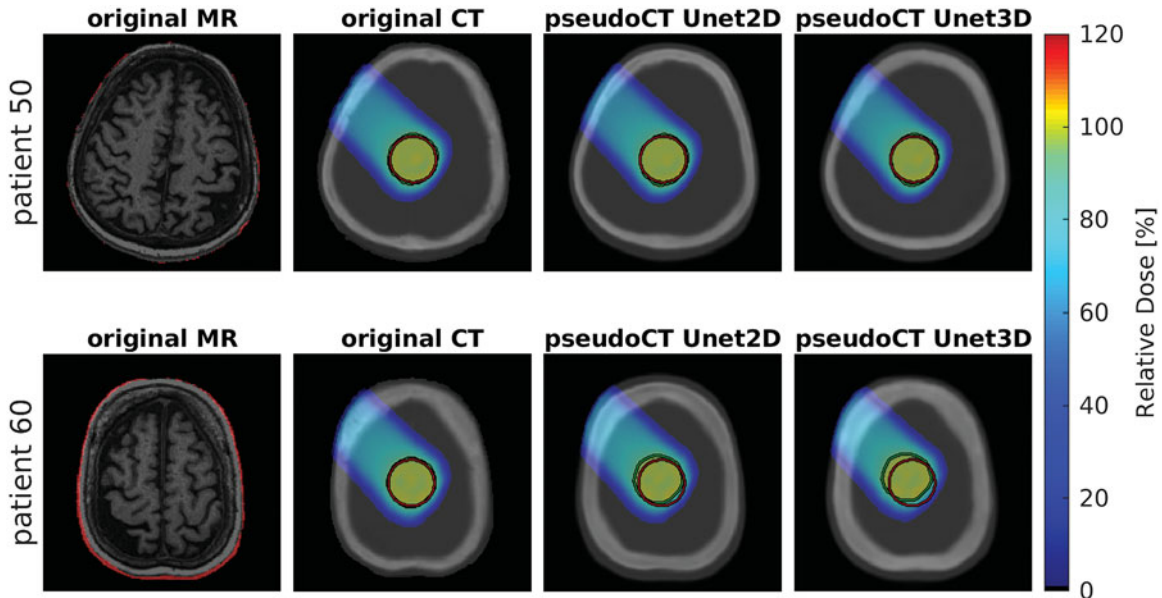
Axial view of the SFUD proton dose distributions for gantry angle  $315^\circ$  of patient 50 and patient 60 (application set) for the CT, the pseudoCT generated by Unet2D and the pseudoCT generated by Unet3D. The generic target is indicated in red and the 95% isodose in green. The dose values were normalized to the prescribed dose. The respective MR slices are shown to the left with the differences between CT and MR patient outlines marked in red.
